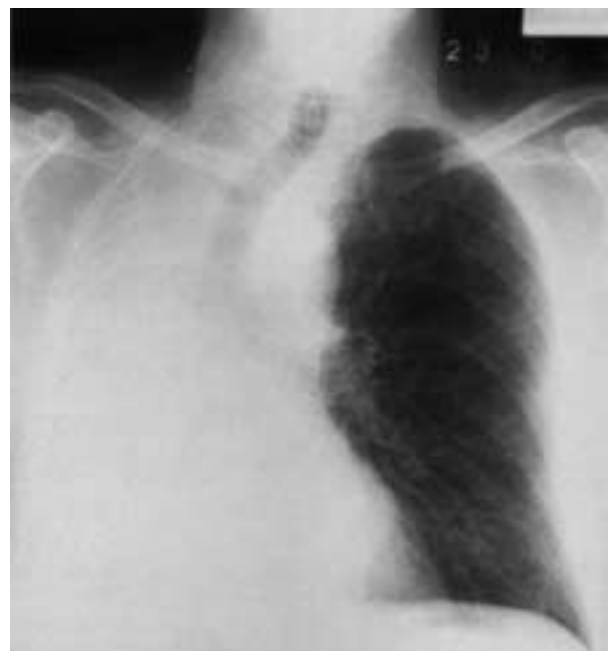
Chest X-ray. The heart and left lung appeared normal.
